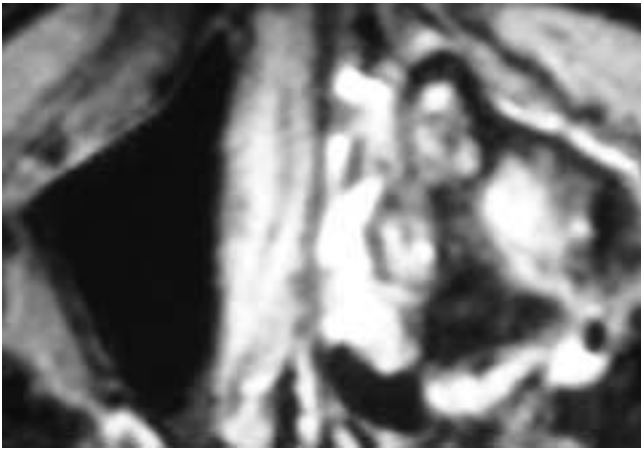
Axial T2-weighted MR image shows a nonhomogeneous mass in the left maxillary sinus. The lesion has extended into the nasal fossa and the infratemporal fossa. This patient had an ameloblastoma. The imaging appearance is similar to that of a minor salivary gland tumor in this sinus.
